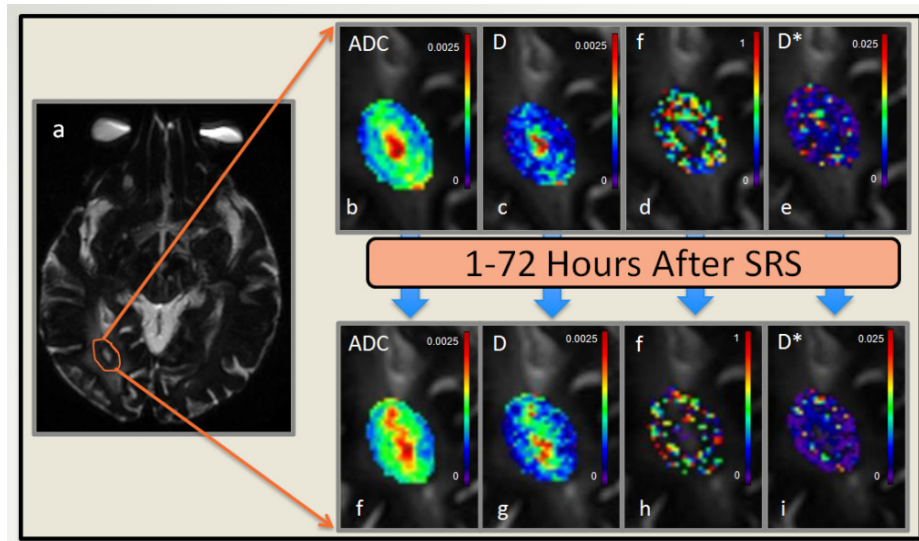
Brain Metastasis patient depicting the early changes in IVIM metrics pre- and early post-Tx. a. A brain metastasis contoured on a T2w MRI. b.-e. pre-Tx ADC, D, f, D* maps. f.-i. Early post-Tx ADC, D, f, D* maps. All maps are overlaid on T2w MRI.
